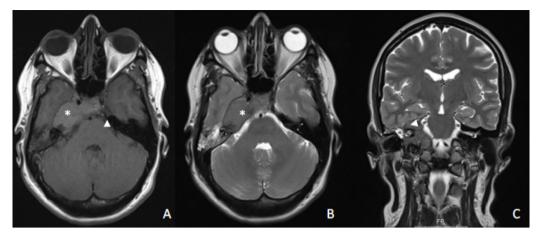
Isointense lesions in both T1 and T2, homogeneous and centred on the right petrosal apex. (A) Axial T1-weighted magnetic resonance without gadolinium showing an infiltrative (*) isointense mass, related to brain tissue, with compression of right trigeminal emergence and temporal lobe remodelling with extension from the temporal bone to clivus. Note the left normal hypointense space (white arrow), filled with cerebrospinal fluid (CSF), related to normal trigeminal left emergence from the midbrain. (B) Axial T2-weighted magnetic resonance without gadolinium showing the same slice in (A). Note the isointense signal from the referred (*) lesion and the hyperintense retention liquid in the mastoid cells. (C) Coronal T2-weighted magnetic resonance without gadolinium showing an isointense lesion (rotated white arrow) filling the right cerebellopontine angle and extension to internal acoustic meatus, with an otic capsule involvement.
